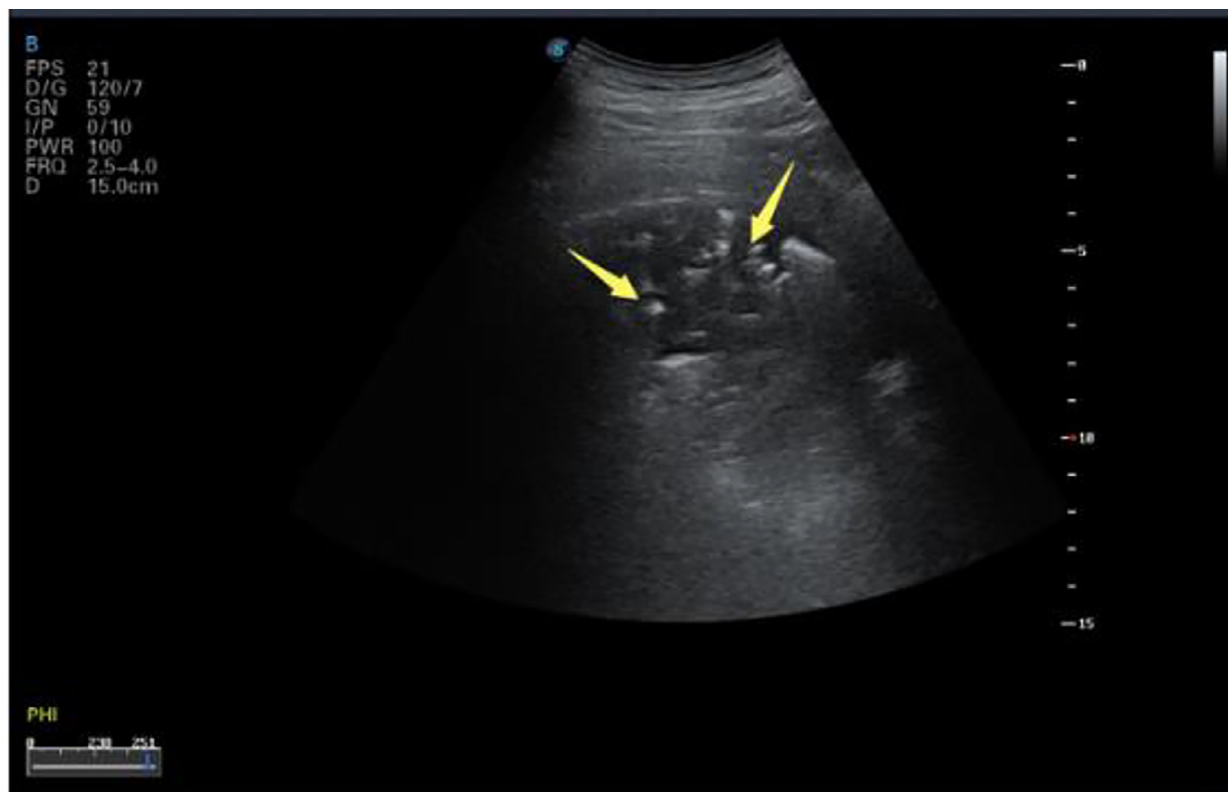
Lung ultrasound image for confirmed COVID-19 patient scanned with a convex-array probe showing large areas of consolidation in the right posterior upper area and air bronchogram sign (yellow arrow). The pleural line is interrupted. Reprinted with permission from Huang et al. (2020).
